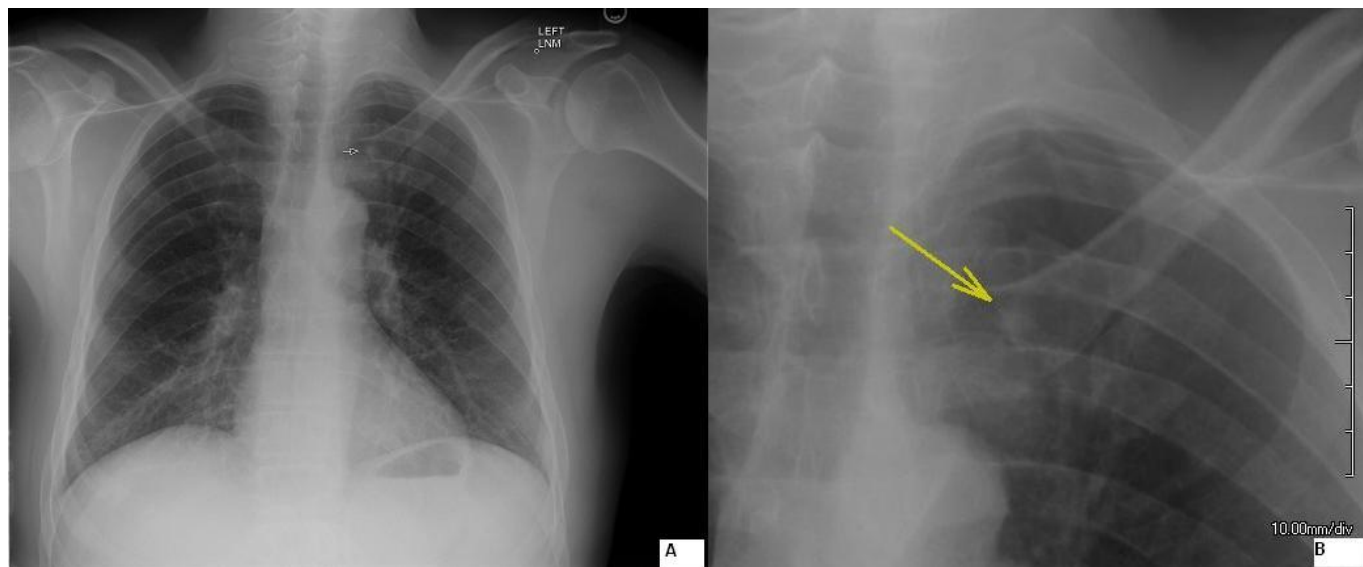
66 year old Male with Left Upper Lobe Partial Anomalous Pulmonary Venous Connection. Image A: PA Chest X-Ray demonstrates an 8mm left upper lobe pulmonary nodule (arrow). The lungs are otherwise clear. Image B: Magnification view better demonstrates the nodule. (Phillips CR)
